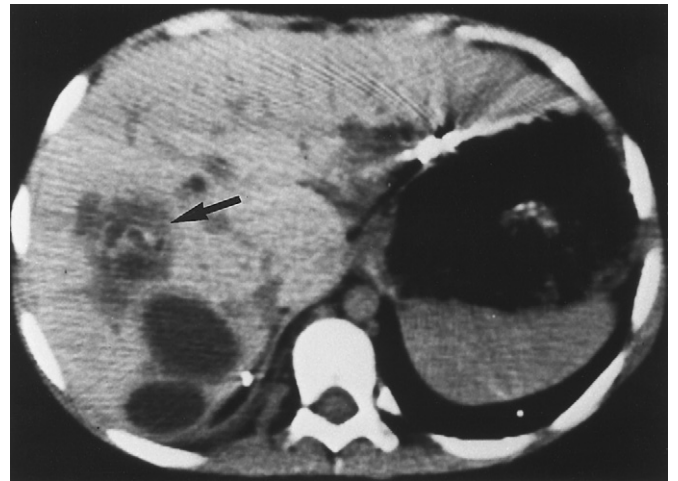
Computed tomography scan demonstrating several hepatic abscesses with one (arrow) containing daughter cysts characteristic of hydatid disease.
